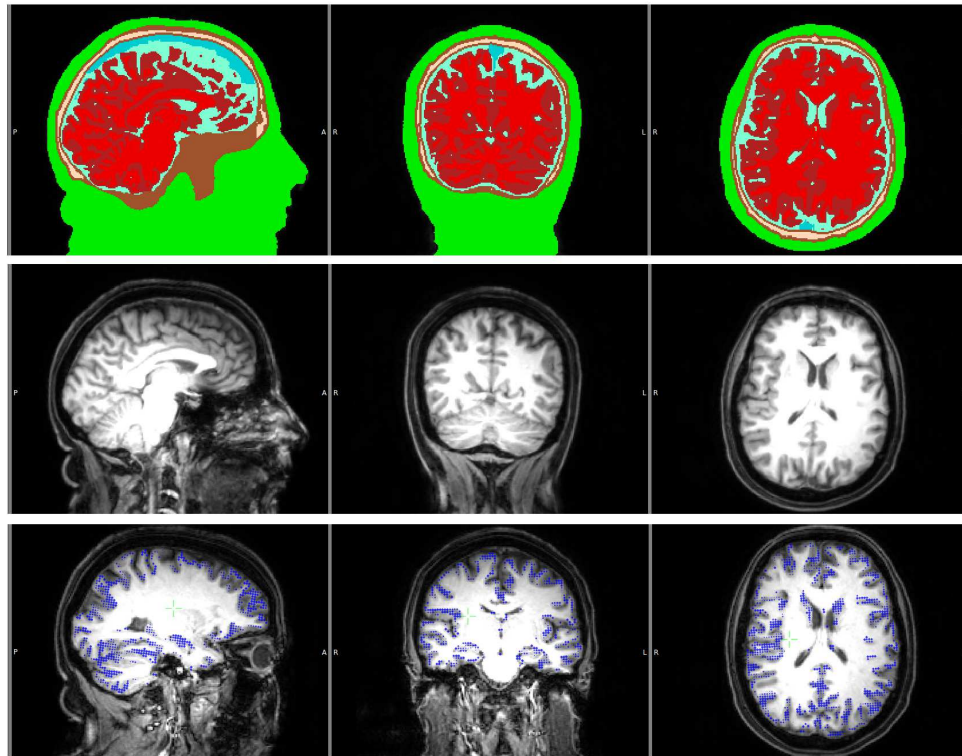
Segmented MRI (upper row), T1 MRI (middle row) and the source space points (blue points) shown on T1 (lower row) MRI. Sagittal (left column), coronal (middle column) and axial (right column) slices. Please note that the slices selected in the lower row are different from the top two rows in order to better visualize the source space points. The color codes for the tissues are scalp (green), skull compacta (brown), skull spongiosa (beige), dura mater (dark turquoise), CSF (light turquoise), gray matter (burgundy) and white matter (red).
